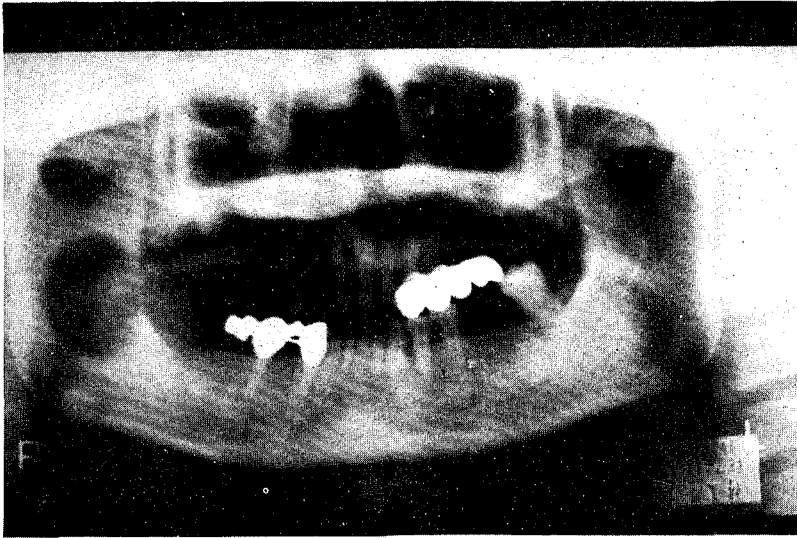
Panoramic radiograph revealed a monolocular radiolucency with irregular border at the ramus of the right mandible.
